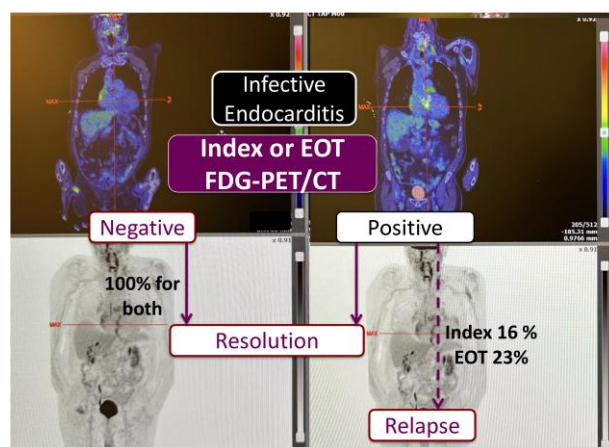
Percentage of infective endocarditis resolution and relapse according to FDG-PET/CT results. Index: first PET/CET examination; EOT: end of antibiotic treatment.
